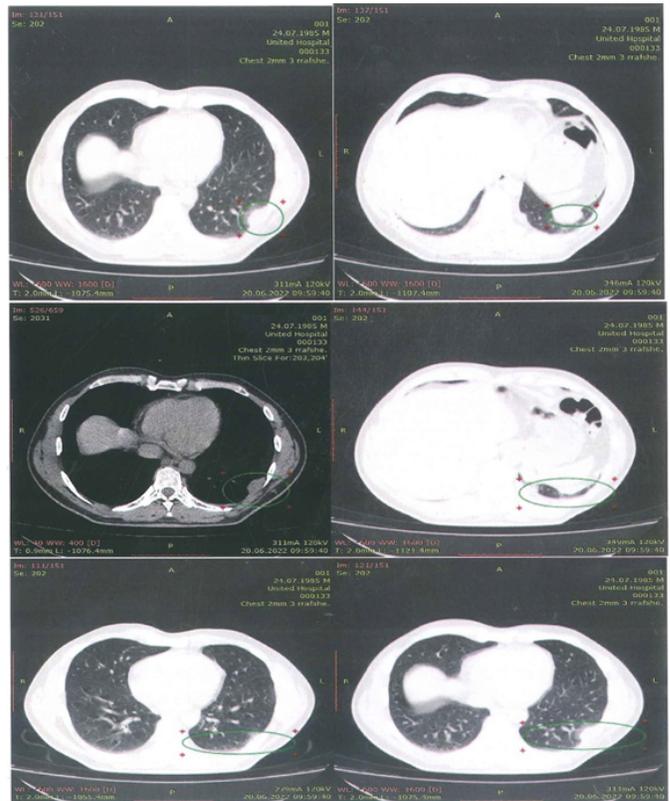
June 2022: Thorax CT before operation.
